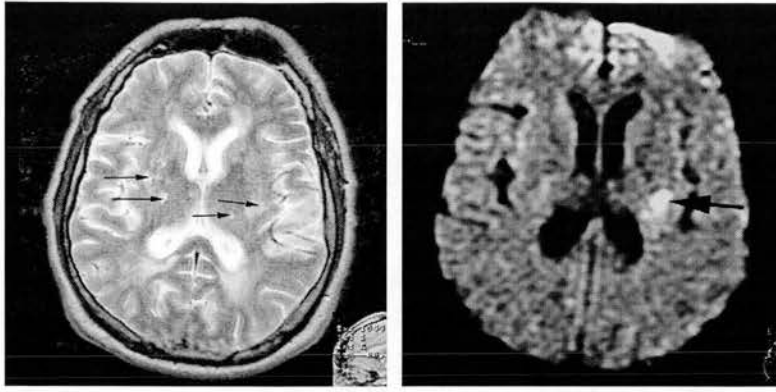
The DWI scan clearly showed lacunar infarcts
